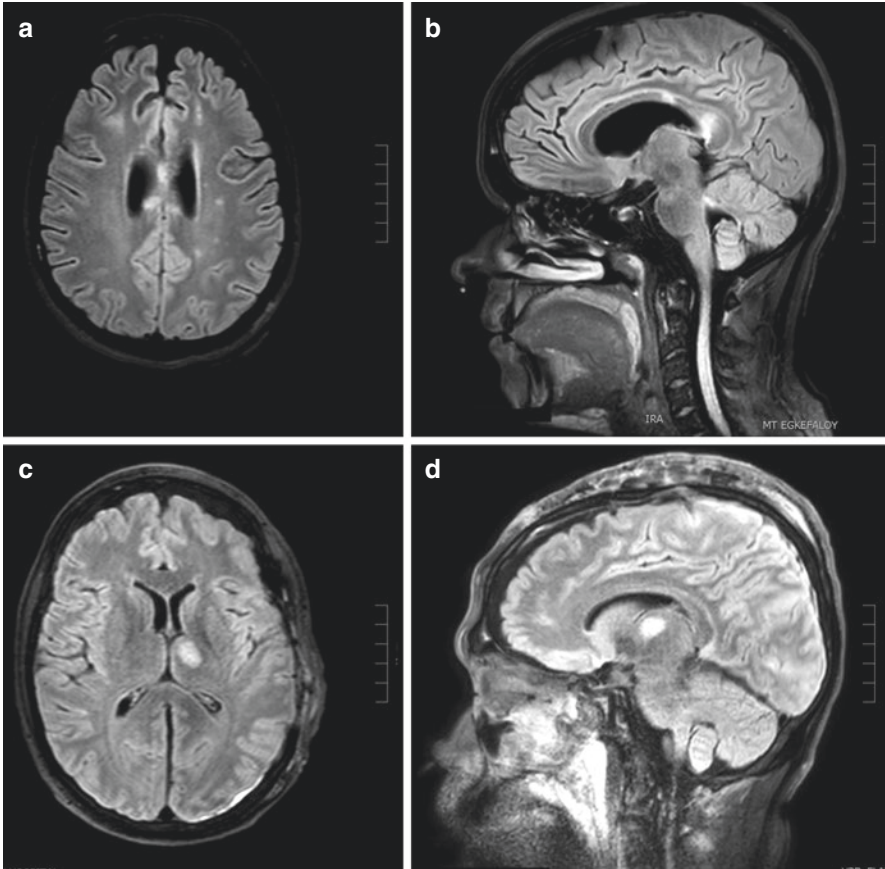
A case of a motor-vehicle accident. The patient was presented in the emergency department in comatose state (GCS 3/15). Brain CT demonstrated bifrontal small posttraumatic subarachnoid hemorrhage. Brain MRI (a, b) that ensued showed multiple hemorrhagic contusions subcortical, in the corpus callosum and in the brainstem (DAI type III). The patient was treated conservatively. (c, d) A case of a motor-vehicle accident. The patient presented at the emergency department in comatose state (GCS 5/15). Brain CT demonstrated a large left frontotemporoparietal acute subdural hematoma with midline shift. The patient was operated. Postoperative MRI revealed a contusion in the left thalamus. Three months later, the patient was discharged with no focal neurological deficit, apart from short-memory loss
